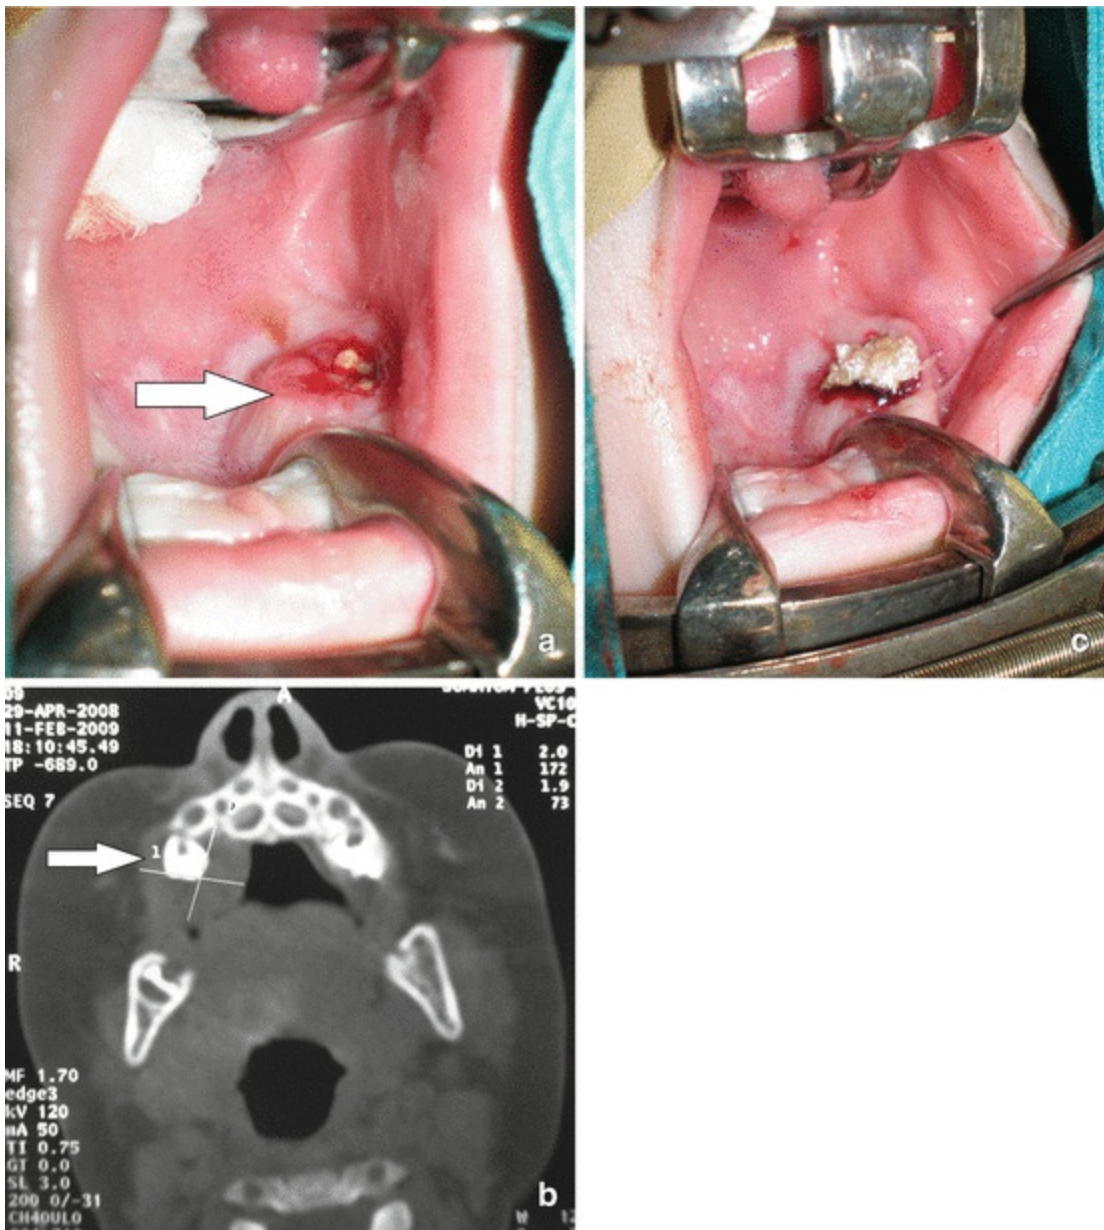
Histiocytosis: (a) Intraosseous localization of the lesion;(b) magnetic resonance imaging; (c) biopsy performed
